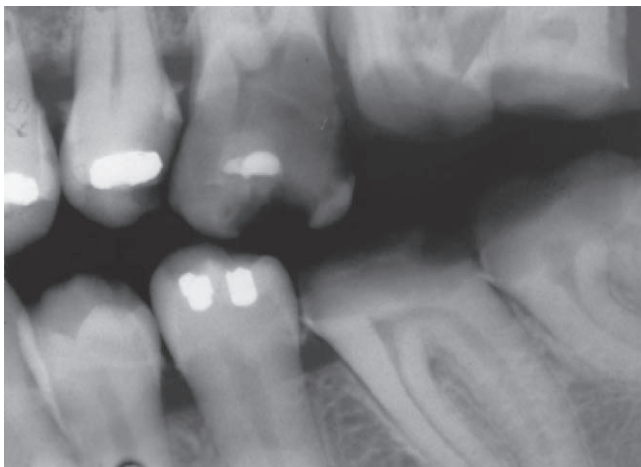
Bite-wing radiographs are especially useful for evaluating the extent of caries in relation to the alveolar crest. In this patient, the maxillary and mandibular molars are probably not restorable.
